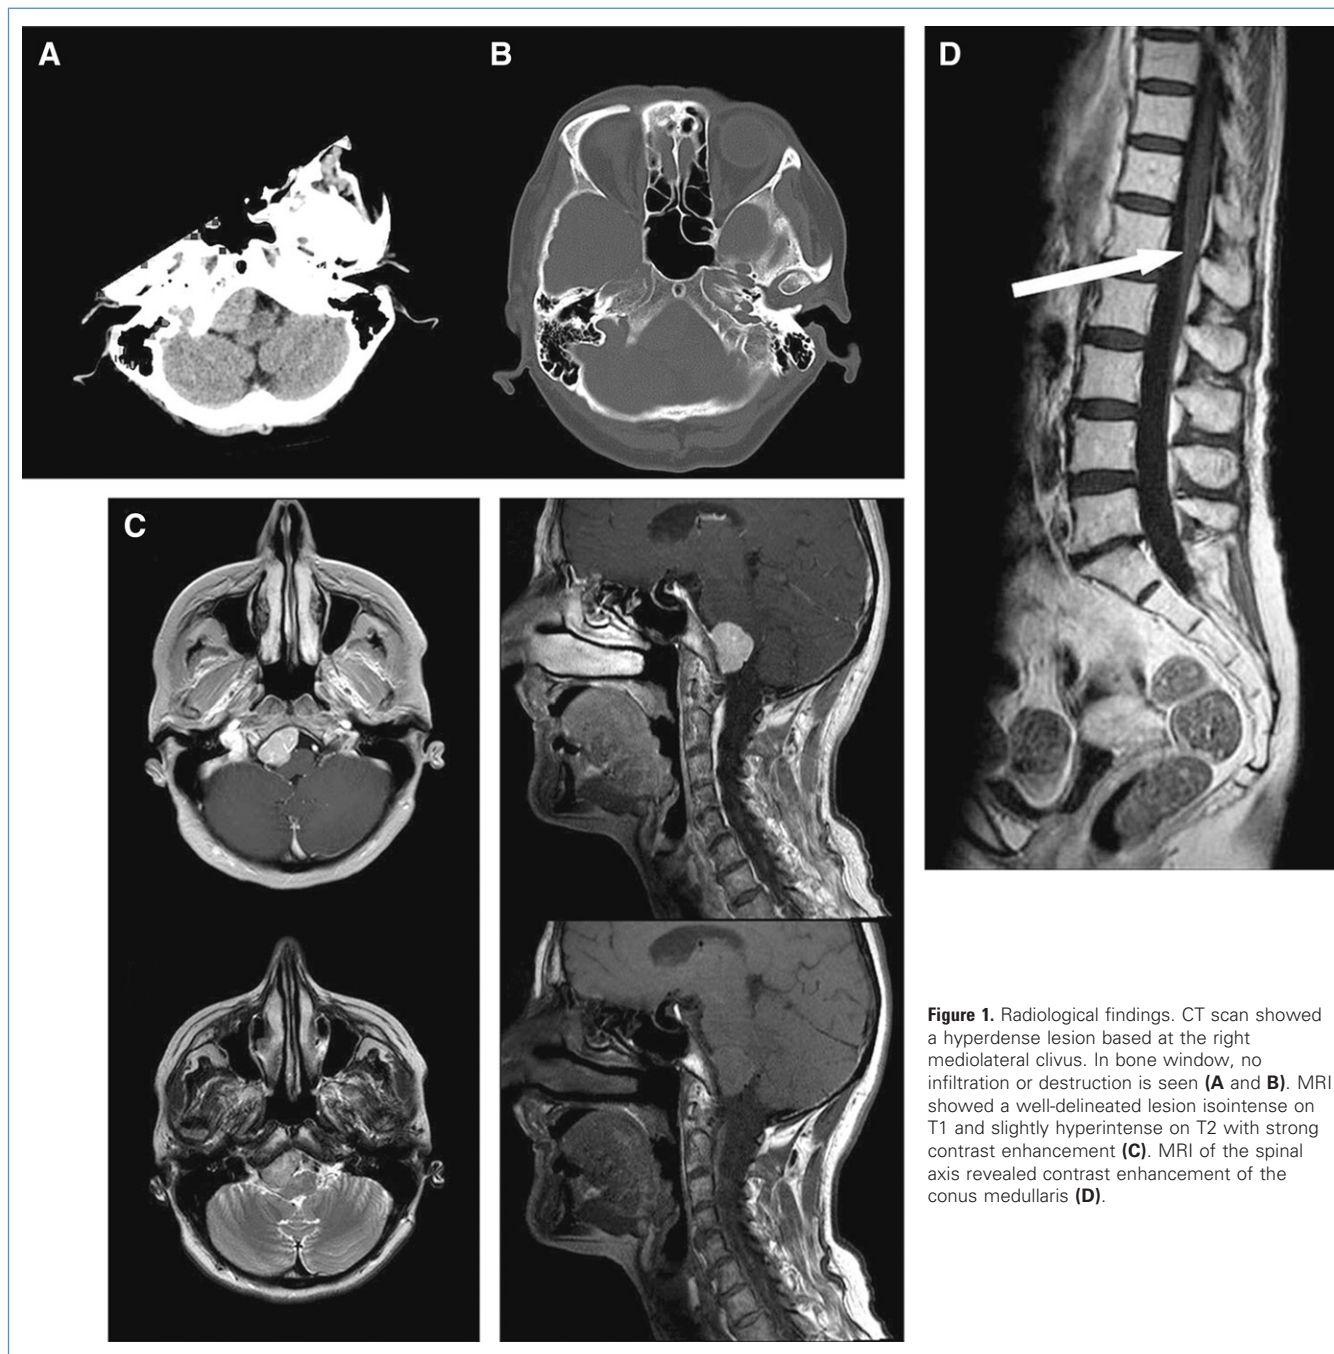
Radiological findings. CT scan showed a hyperdense lesion based at the right mediolateral clivus. In bone window, no infiltration or destruction is seen (A and B). MRI showed a well-delineated lesion isointense on T1 and slightly hyperintense on T2 with strong contrast enhancement (C). MRI of the spinal axis revealed contrast enhancement of the conus medullaris (D).
